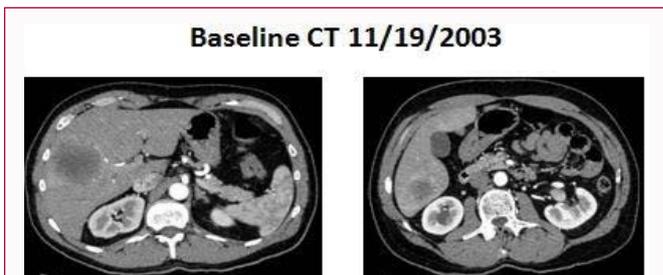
Case B. CT 11/19/2003, revealed multiple liver metastases. CT 05/12/2004, is status post chemotherapy and right PVE and shows a significant reduction in size of liver metastases.
